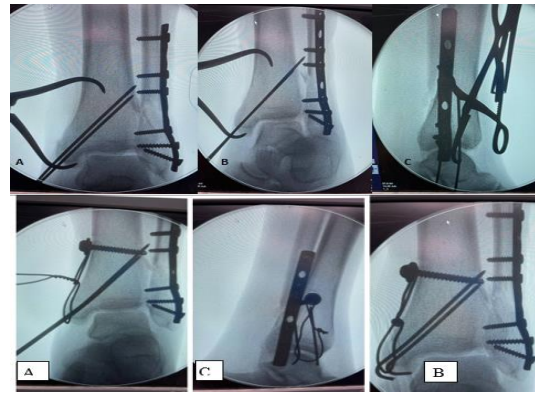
Radiographic images demonstrating the reduction of the medial malleolus using a clamp and fixation with K-wires; a. anteroposterior (AP) view, b. mortise view, c. lateral view.
